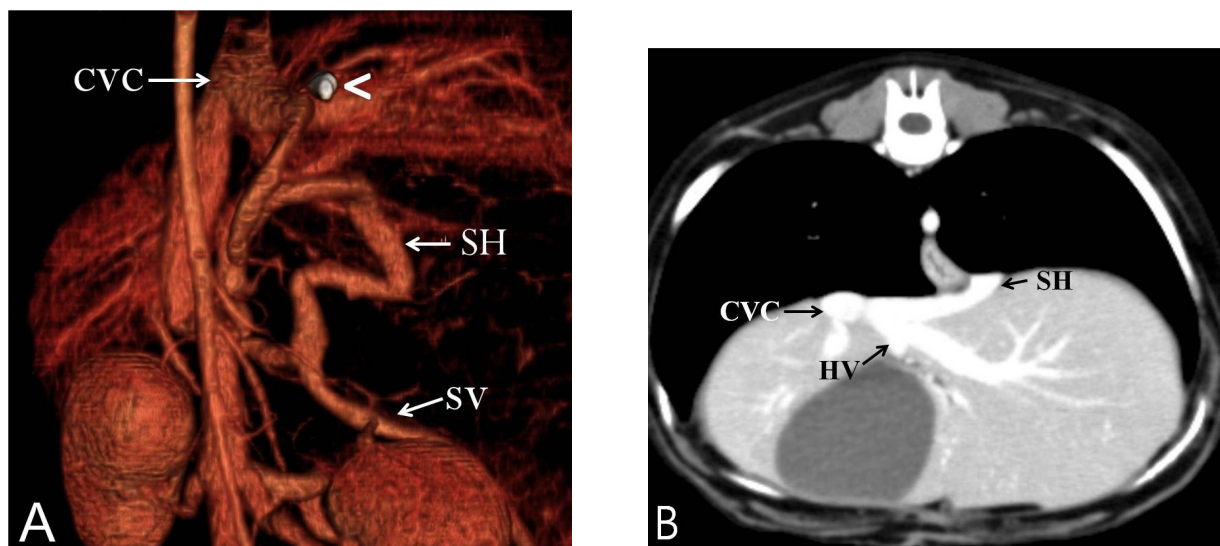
Postoperative volume-rendered imaging (VRI, A) and transverse computed tomography angiography image (CTA, B) 10 months after surgery: A haemoclip (arrow head) used to secure the cellophane band is identified on VRI. There is evidence of portosystemic communication and no attenuation of the shunt on the level of the cellophane band on CTA and VRI. CVC = caudal vena cava; SH = shunt; SV = splenic vein; HV = hepatic vein
